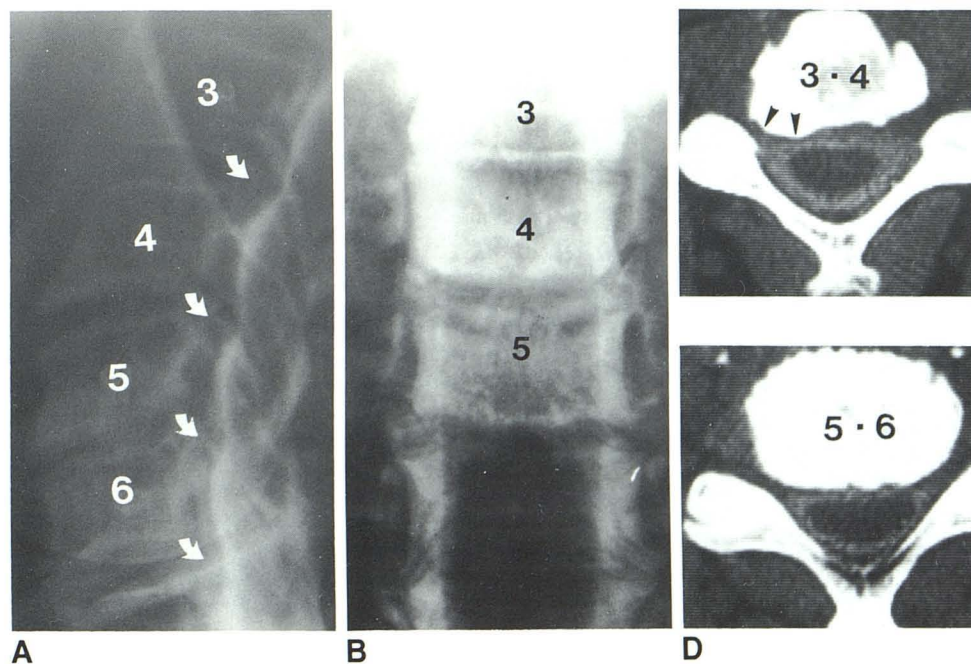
50-year-old man with neck and right shoulder pain. A, Lateral myelogram. Double density at C3–C4 level (arrow). There was no evidence of lateralization on frontal view. B, CT myelogram. Focal spur on right (arrowhead) with focal obliteration of ventral space. Symptoms improved after removal of C3–C4 osteophyte via anterior discectomy.
